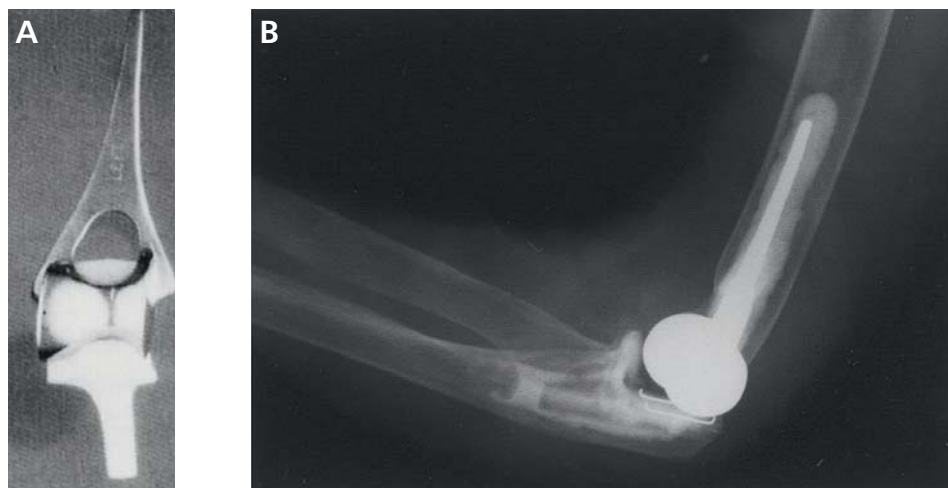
Preoperative anteroposterior photograph (a) and postoperative lateral radiograph (b) showing the long-stemmed humeral component and standard-sized ulnar component.
